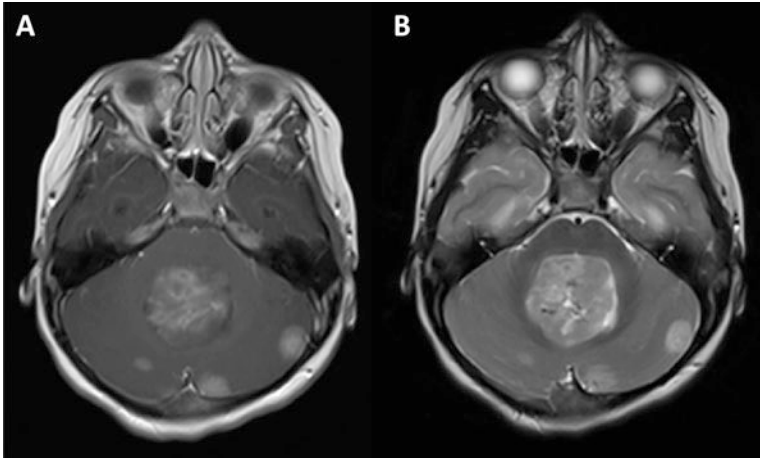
Five year old with multifocal medulloblastoma with a heterogeneous mass in the fourth ventricle and several other enhancing lesions in the posterior fossa. (a) T1 post-gadolinium image. (b) T2-weighted image
